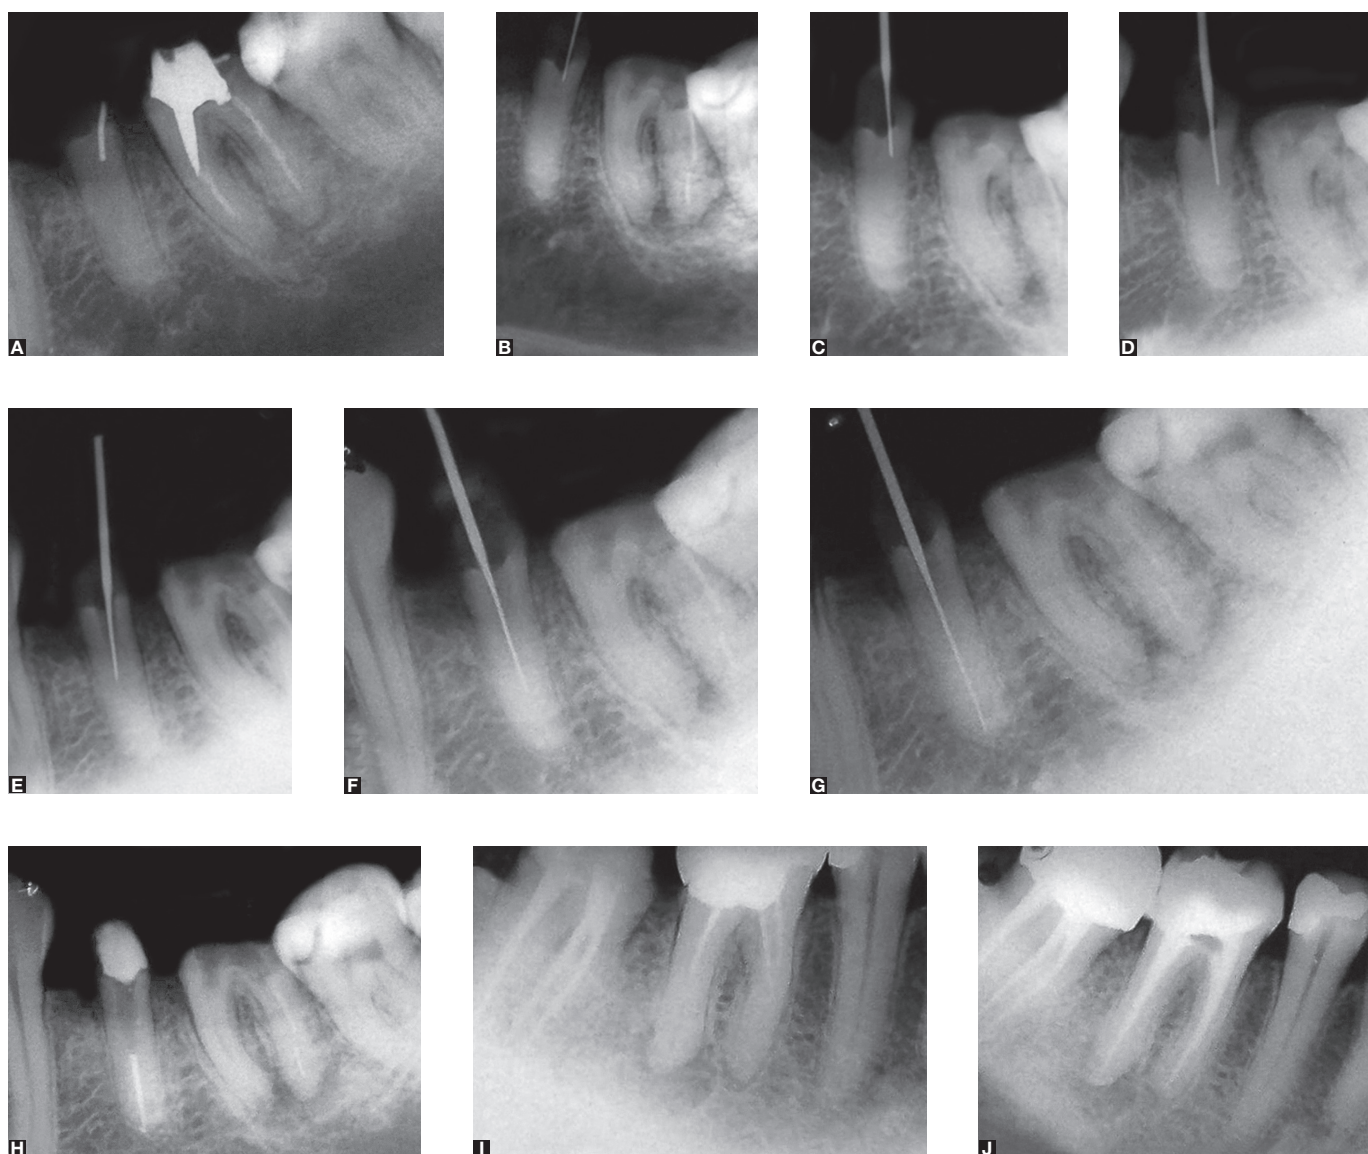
(A) Preoperative radiograph. A dentin post can be noticed. Initial access. (B) The tooth was isolated without clamp. (C) Angulated radiograph demonstrating buccal deviation. 1-2mm apical insertion. (D) The deviation persisted. (E) After correction in the file position, it was inserted 1-2mm apically. (F) It seems to be mesially dislocated. (G) Deviation correction. (H) Patency reached. Final radiograph. Preoperative radiograph. (I) The mesial root canals are completely obliterated. (J) Final radiograph demonstrating success in root canal re-treatment.
